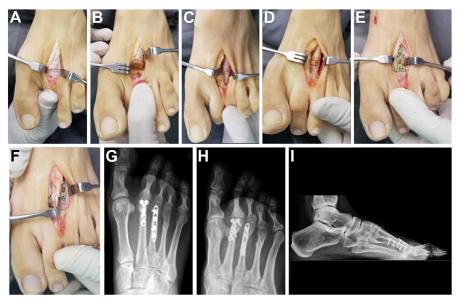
Metatarsal malunion surgical correction: (*A*) longitudinal incision between M2 and M3 provided access for both metatarsals. Note the M2 dorsal apex malunion. (*B*) Incomplete closing wedge osteotomy at the M2 deformity apex. (*C*) M3 visualization provided by the incision. (*D*) Delimitation of M3 incomplete closing wedge osteotomy at the deformity apex. (*E*) M2 fixation with a 2.7-mm locking plate. As the distal M2 segment was short, a "T" plate was chosen, affording more stability. (*F*) M3 fixation with a 2.7-mm locking plate. (*G*) The fourth-month postoperative weight-bearing foot X-Ray (anteroposterior view). Note the metatarsal formula reestablished and complete osteotomy consolidation. (*H*) The fourth-month postoperative weight-bearing foot X-Ray (oblique view). Note the correction of the flexion deformity. (*I*) The fourth-month postoperative weight-bearing foot X-Ray (complete view). Note the metatarsal formula reestablished and complete osteotomy consolidation. (*H*) the fourth-month postoperative weight-bearing foot X-Ray (complete view). Note the correction of the flexion deformity. (*I*) The fourth-month postoperative weight-bearing foot X-Ray (complete view). Note the metatarsal formula reestablished and complete osteotomy consolidation.
